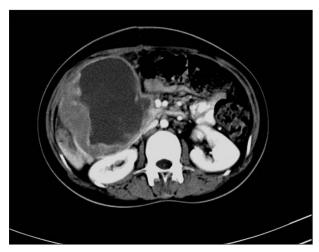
Contrast enhancing CT axial image showing heterogeneously enhancing mass in the head and uncinate process of pancreas with necrosis within
